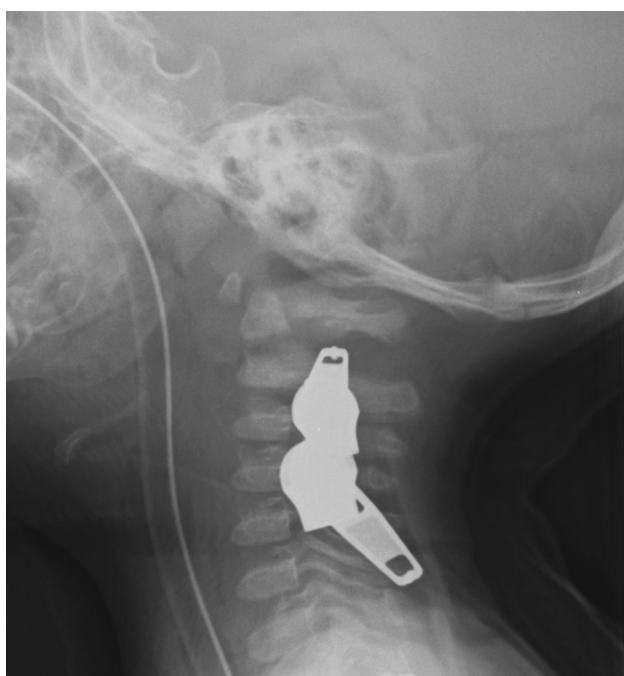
An immediate postoperative lateral view of the cervical radiograph shows good alignment of the atlantoaxial joint with the Minerva cast
